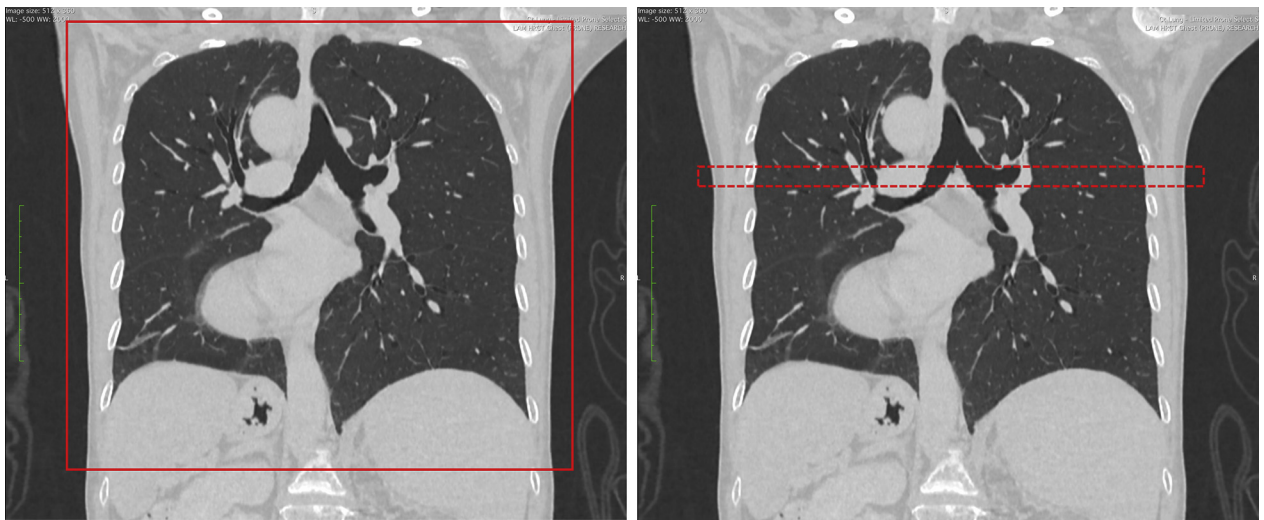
Screenshots from the scanner console showing the coverage of the standard helical chest CT scan on the left and the research regional, ultra-high resolution CT scan on the right. In these coronal projection views, the standard scan covers the entire chest, shown by the red rectangle in the left image; the regional, ultra-high resolution CT scan covers a mid-segment of the chest of 20 mm length (dotted red rectangle in the right image).
